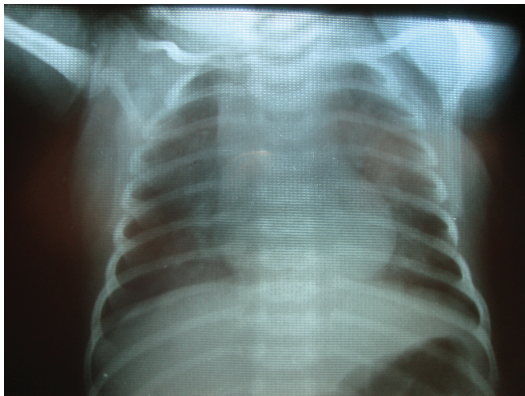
Chest X-ray revealing a homogeneous opacity consistent with bronchopneumonia. Image taken before treatment with BAL.
